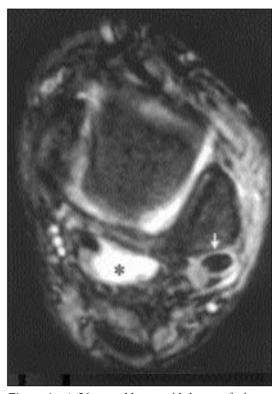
A-26-year-old man with lung, soft tissue, bone and tendon involvement. Axial T2-weighted MR image of left ankle shows increased thickness and increased signal intensity in cutaneous and subcutaneous tissues. Note also thickening and increased signal intensity in the tendons of perenous brevis and longus due to spreading of infectious process neigbouring tissues (white arrow). Note also synovial cyst as increased signal intensity protruding posterior to the joint (asterisk).
